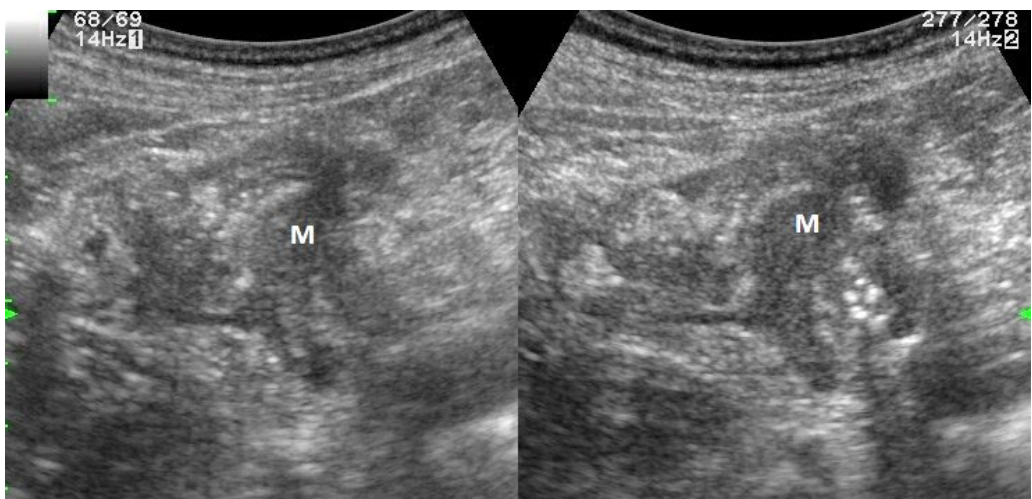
Ileocecal valve infiltration (M) by an adenocarcinoma. A bezoar forming in front of the ileocecal valve can be seen to the right of the split-screen ultrasound image
